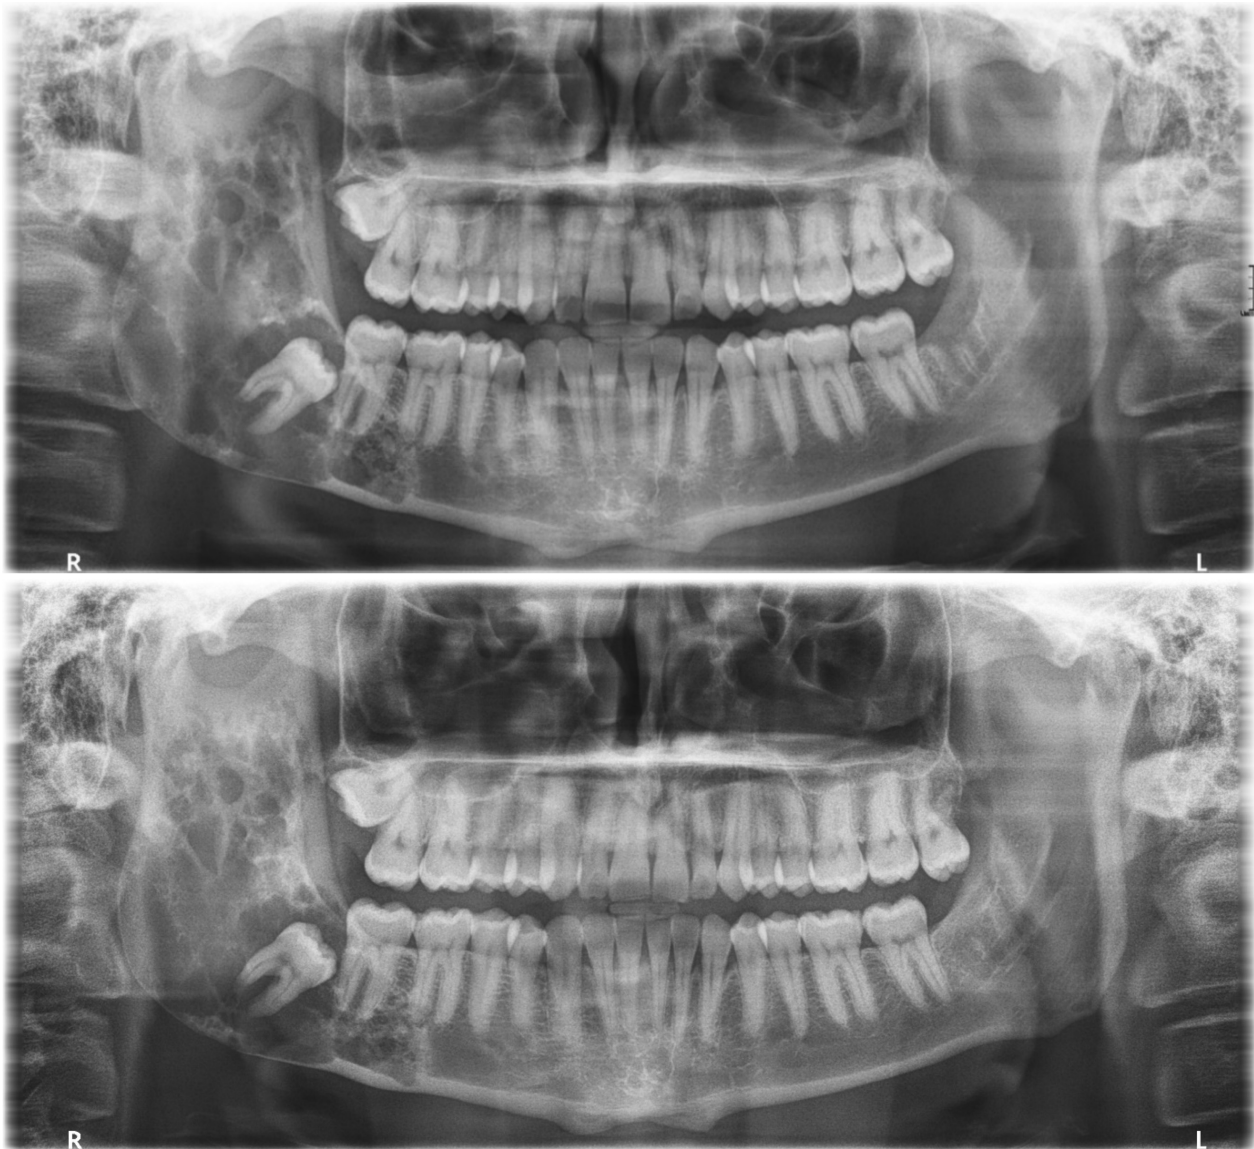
Two full orthopantomogram radiographs showing a multilocular radiolucency in the right mandible. The lesion appears unchanged in the 11 months between the initial assessment (top) and the review appointment (bottom).
